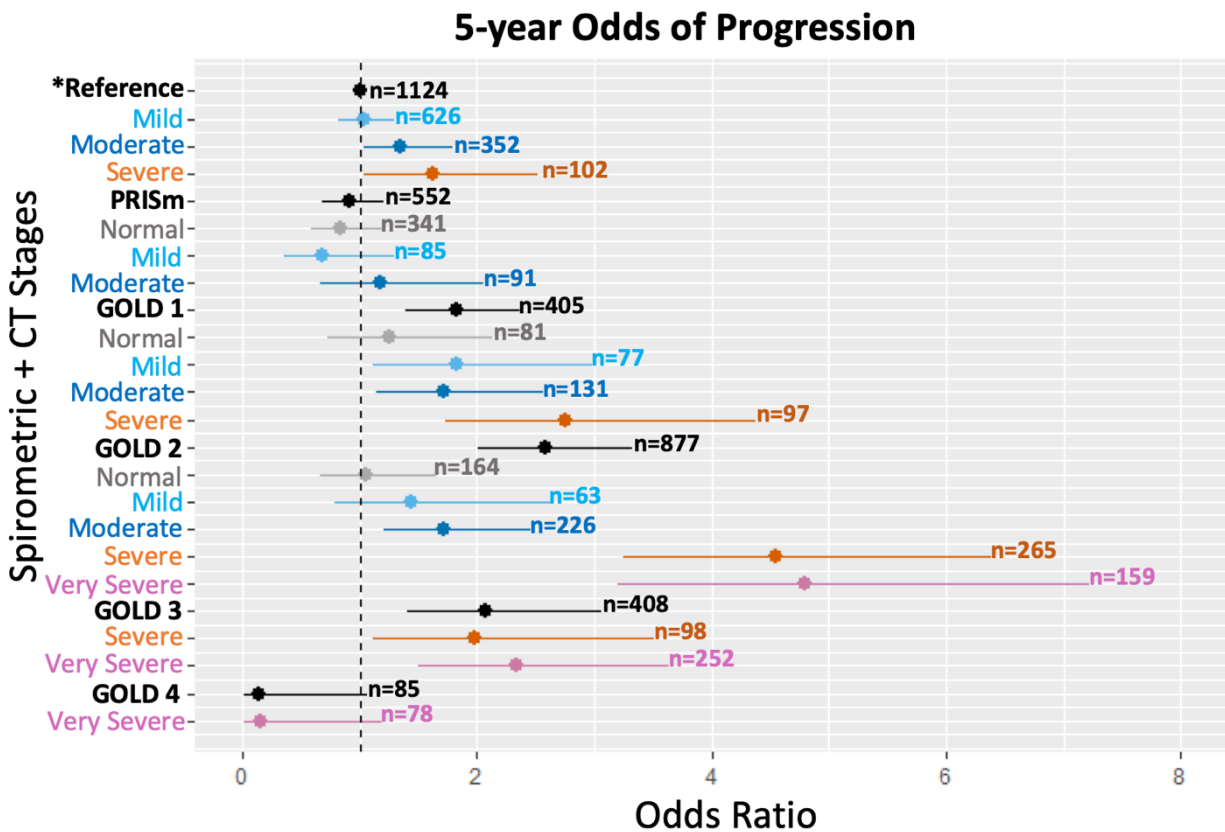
Analysis of FEV₁ progression using both imaging and spirometry as predictors showed significant interactions. Amongst patients with GOLD 2 disease, severe to very severe disease on CT showed higher likelihood of progression.
